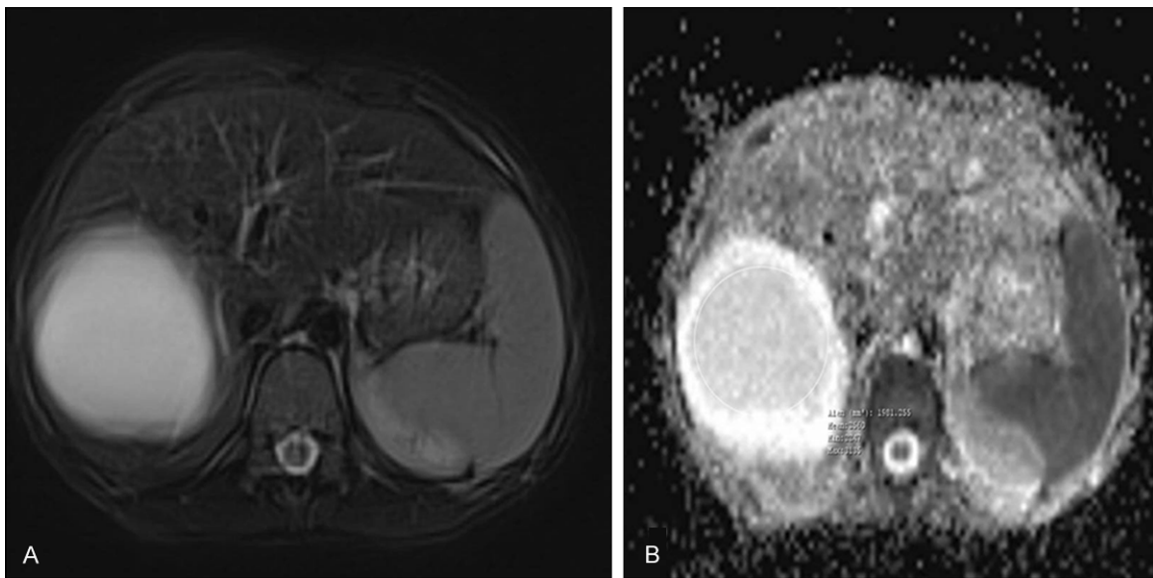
Magnetic resonance images of 9-year-old girl patient with type 1 hydatid cysts. A. Axial T2-weighted fast spin-echo MRI. B. ADC map show type 1 hydatid cysts in segment 7-8 of the liver. ADC value of postoperative residual cavity is $2.56 \times 10^{-3} \text{ s/mm}^2$.
